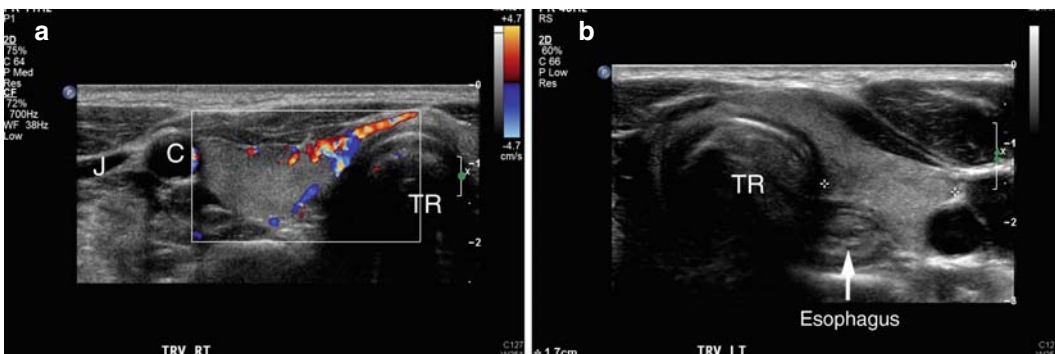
Normal thyroid anatomy seen on transverse ultrasound images (A) Normal right with doppler. Trachea is seen as a midline structure (TR), and carotid artery (C) and internal jugular vein (J) are seen bilaterally (B) Normal left. The esophagus is seen on the left posteriorly.
